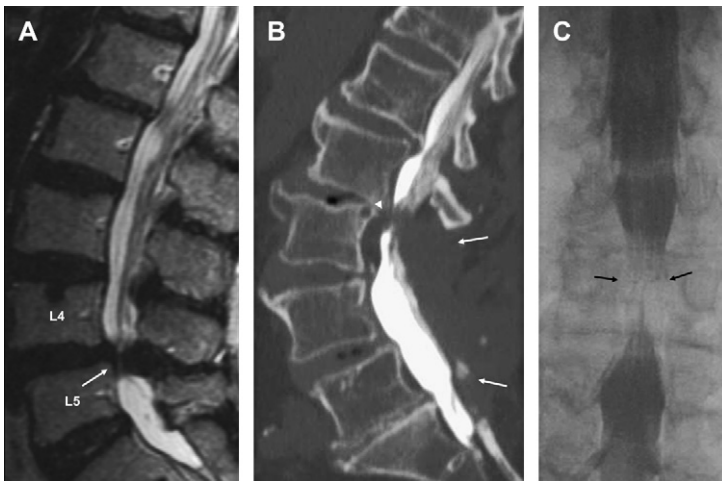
Spinal stenosis. (A) Sagittal T2—severe central canal stenosis a result of mild disk bulging and dominant LFH at L4-L5. Note mild L4-5 anterolisthesis. (B, C) Acquired central canal stenosis. Sagittal CT myelogram (B)—severe thecal sac compression resulting from retrolisthesis and associated hypertrophic changes (*arrowhead*). Note lumbar spine decompression laminectomies (*arrows*). Corresponding conventional myelogram posterior-anterior image (C) showing thecal sac defect (*arrows*).
